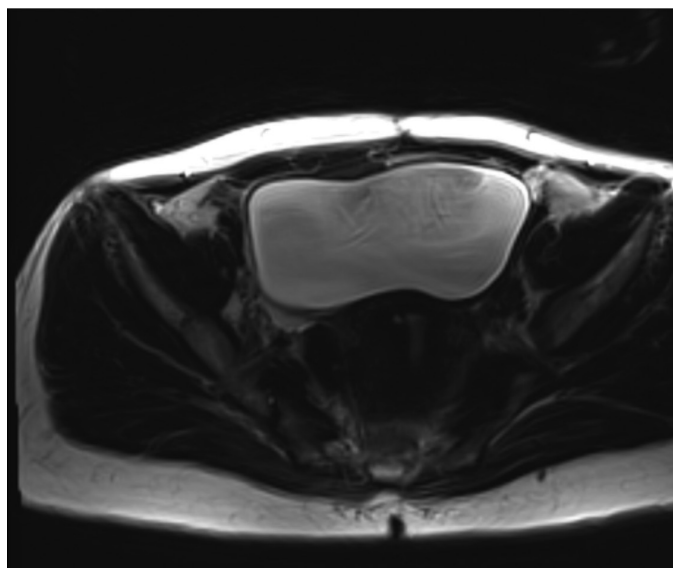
MRI shows that the bladder is intact after 4 year follow-up after combination treatment
